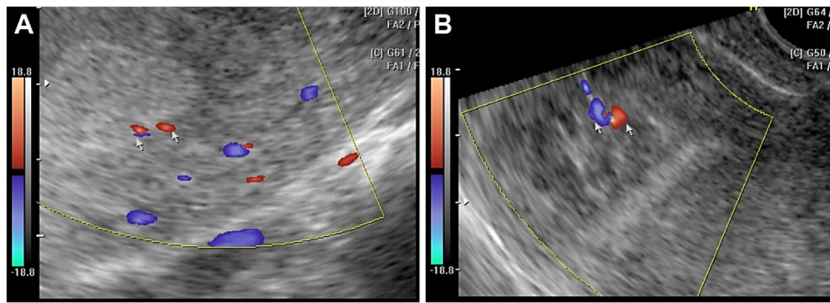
TVUS demonstrating EP: (A) Color Doppler TVUS demonstrating the vascularity of the EP; (B) Color Doppler TVUS demonstrating the vascularity of the EP as an elongated and branching spiral artery. EP: Endometrial polyp; TVUS: Transvaginal ultrasound.
